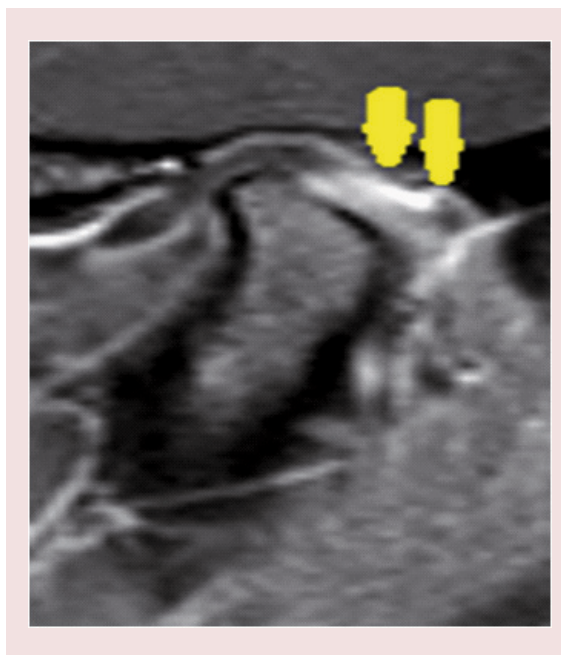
Temporomandibular joint MRI (sagittal T1-weighted post-contrast image) of 17-year-old female with juvenile idiopathic arthritis limited to her temporomandibular joint, who has received multiple rounds of IAC and IA infliximab. A thickened and enhancing synovium (pannus) is evident (arrows).
